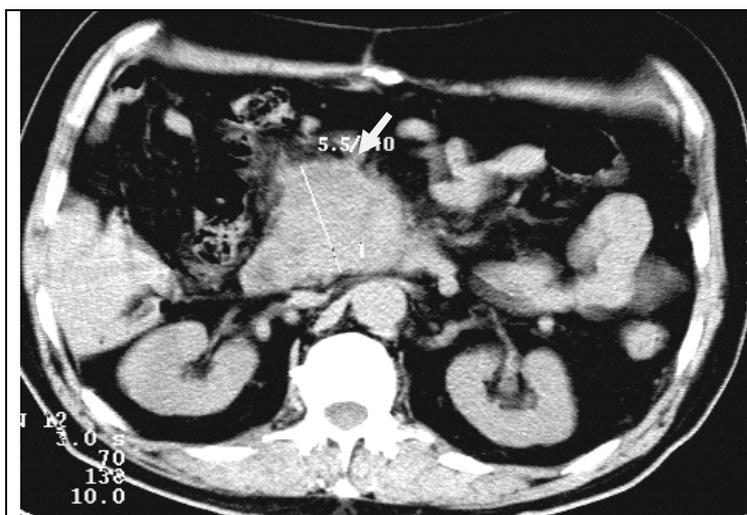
CT-scan. Carcinoma of the head of the pancreas. Large irregular mass originating in the pancreatic head with lower and heterogenic attenuation.
